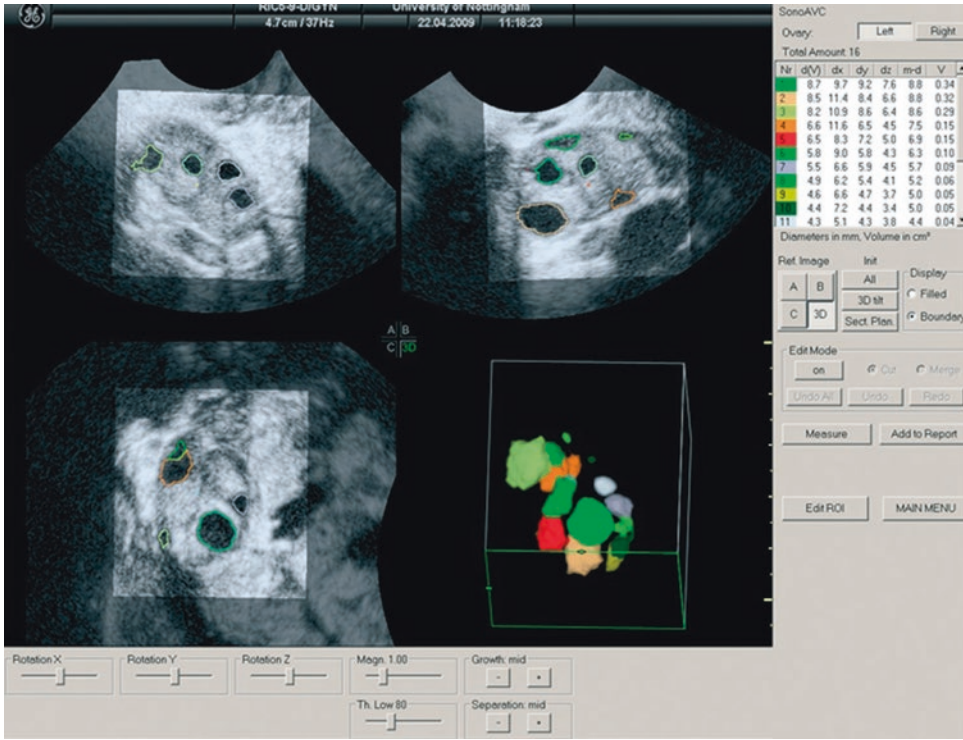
Multiplanar display of an ovarian three-dimensional ultrasound dataset by SonoAVC. Each follicle has a specific color, and its measurements are displayed
